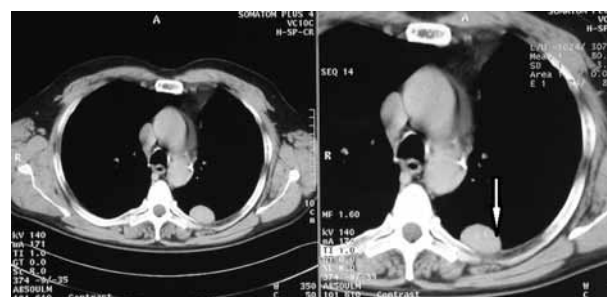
Thoracic computed tomography – lobulated pleural-based mass in the posterior segment of the upper lobe
